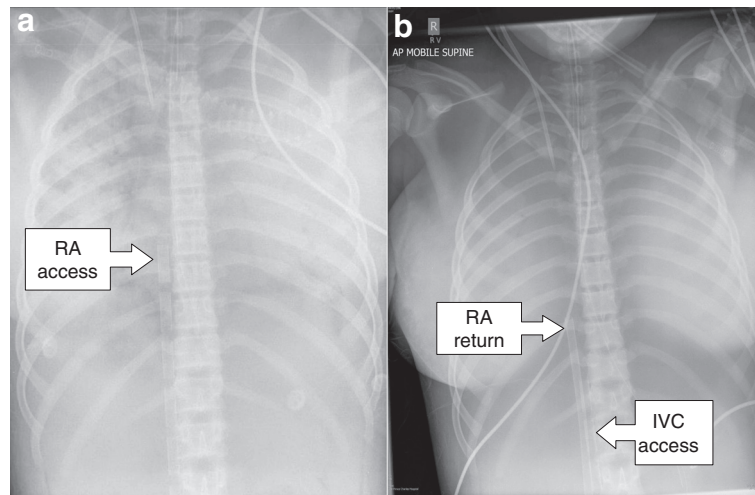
Patient *in extremis* initially receiving femoro-femoral venoarterial extracorporeal membrane oxygenation (ECMO) with transition to venovenous ECMO. Patient *in extremis* initially received femoro-femoral venoarterial (VA) ECMO for severe cardiorespiratory failure with transition to venovenous (VV) ECMO on day 4 following satisfactory cardiac recovery. (a) Chest X-ray scan shows multistage access cannula in the right atrium (RA) during VA ECMO, (b) which was later withdrawn into the inferior vena cava (IVC) during VV ECMO. (b) A venous return cannula can also be seen in the right atrium.
